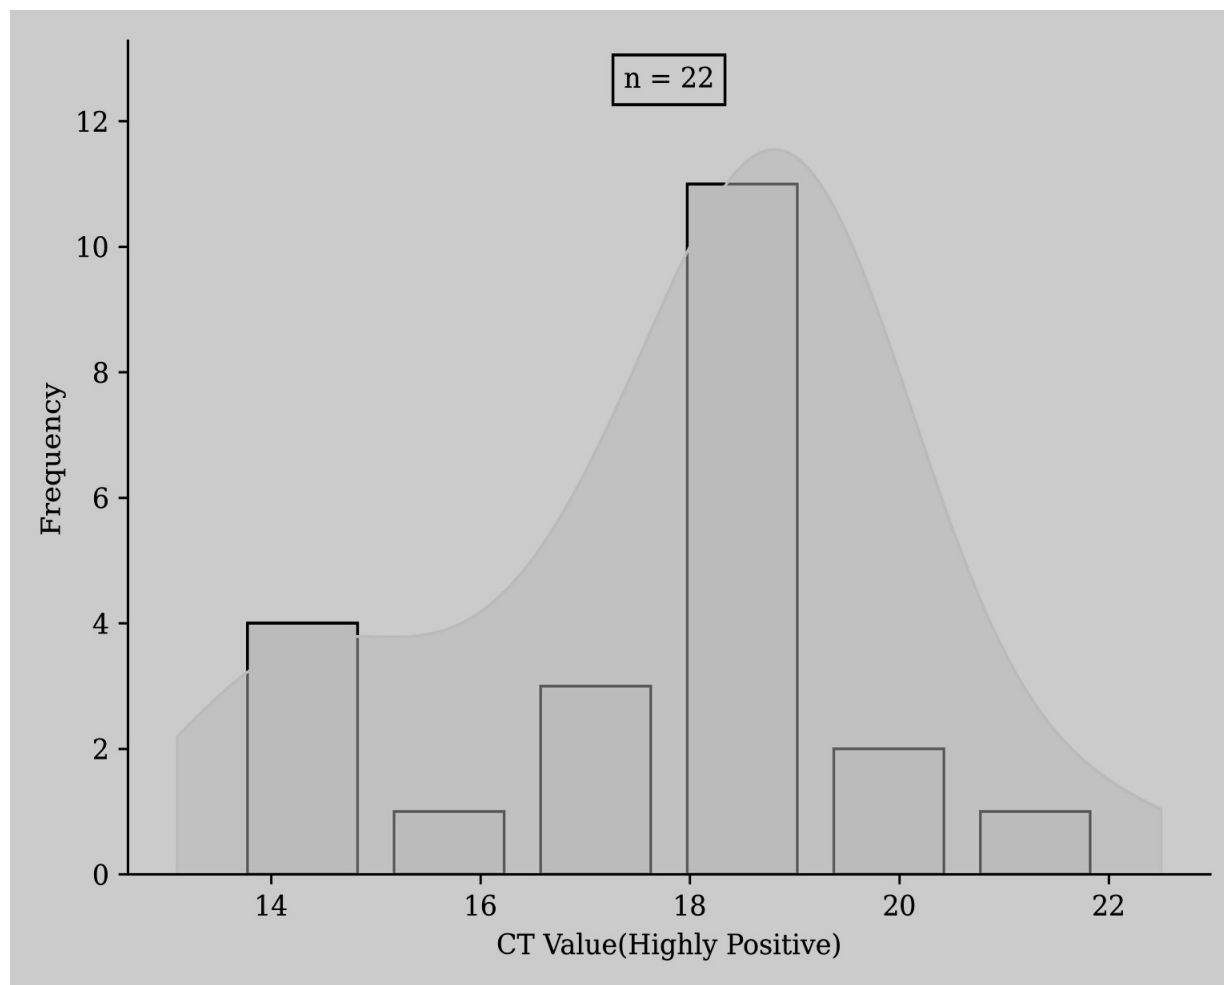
Graph representing Highly positive CT values of Covid-19 patients.
